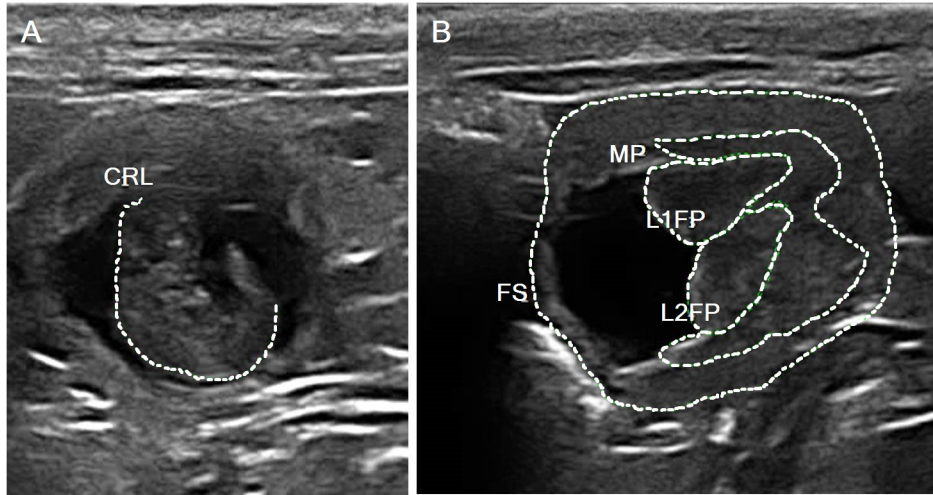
Ultrasonography measurements of foetus (A) and placentas (B)
